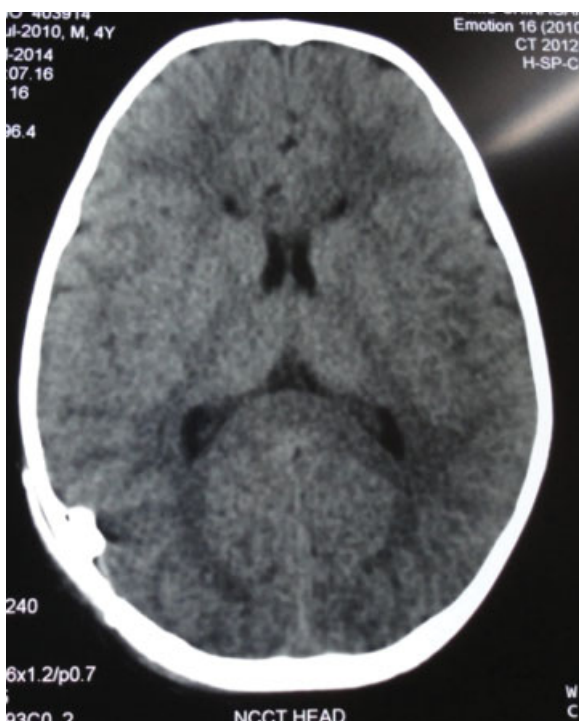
Plain CT scan head shows right parietal depressed fracture with in-driven broken stones mistaken for bone pieces.
